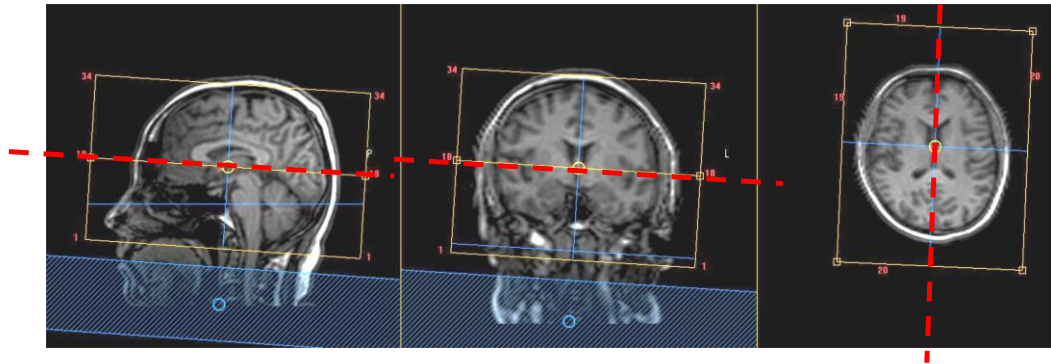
MRI survey showing example of SMARTEXAM automated planning. (Dotted red line shows alignment of slices through anterior/posterior commissure line and perpendicular to this line on coronal and transverse planes). (Images are from the SABRE v3 study).
